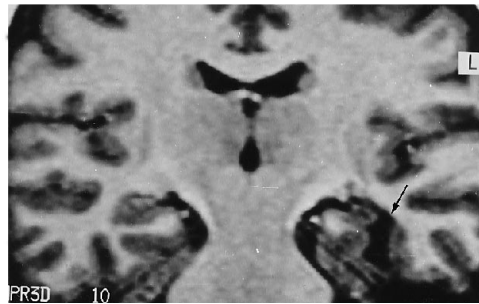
Patient 7: cleft of the left temporal lobe. Oblique coronal T1-weighted section: a cleft occupied the left occipitotemporal gyrus (arrow). This cleft extended from the temporal horn to the surface of the brain and was suggestive of a limited form of schizencephaly. The left hippocampal formation was atrophic.
